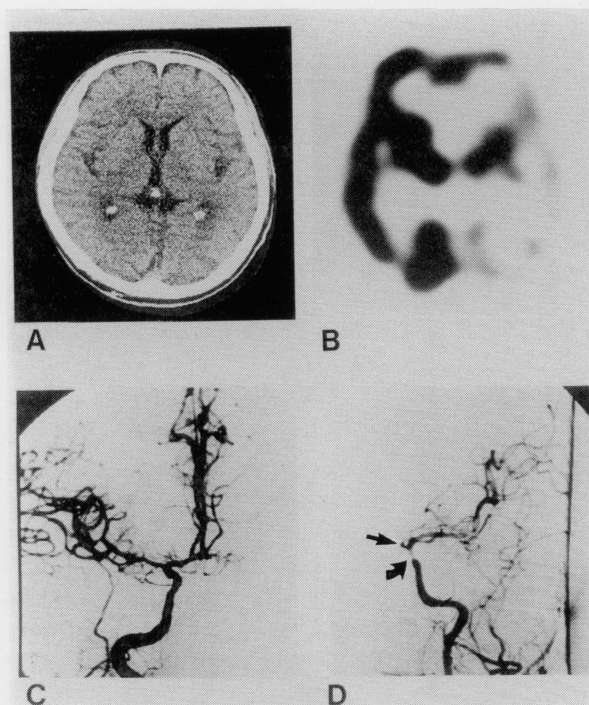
A: CT in a 68-year-old male 10 days after a transient symptom of right hemiparesis showing no hypodense area. B: SPECT at the same level 14 days after TIA showed a prominent hypoperfused area in the frontal, parietal, temporal, and occipital cortices on the left hemisphere. C and D: Cerebral angiogram revealed severe stenosis (>90%) in the cavernous portion of the left internal cerebral artery (ICA) and occlusion of the left anterior cerebral artery (ACA) (indicated by arrows) (D). The blood flow in the left ACA was supplied from the contralateral ICA through the anterior communicating artery (C).
